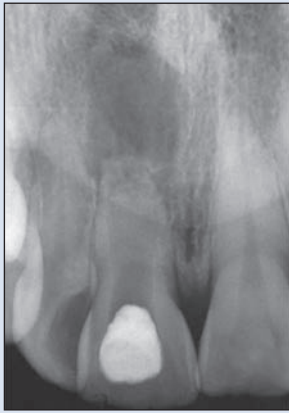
Follow-up radiograph after 5 years showing deposition of hard tissue in the apical area.
